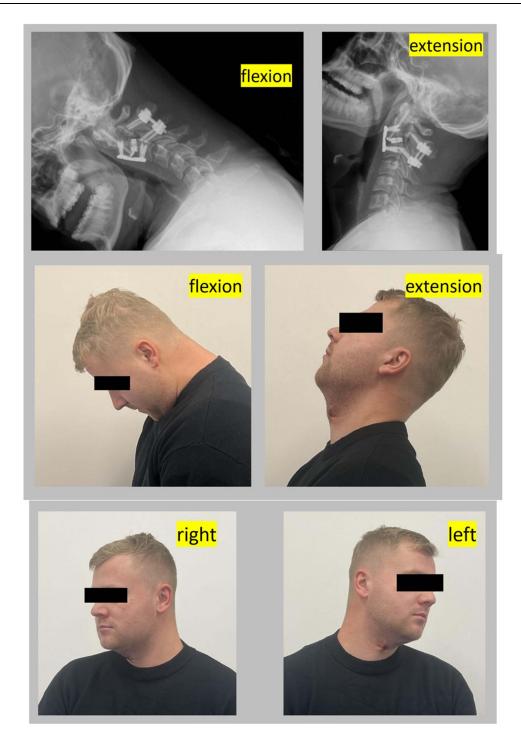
Functional radiograph of cervical spine and photographs of the patient at 8 weeks after the procedure showing intact flexion/extension and rotational head movements.
